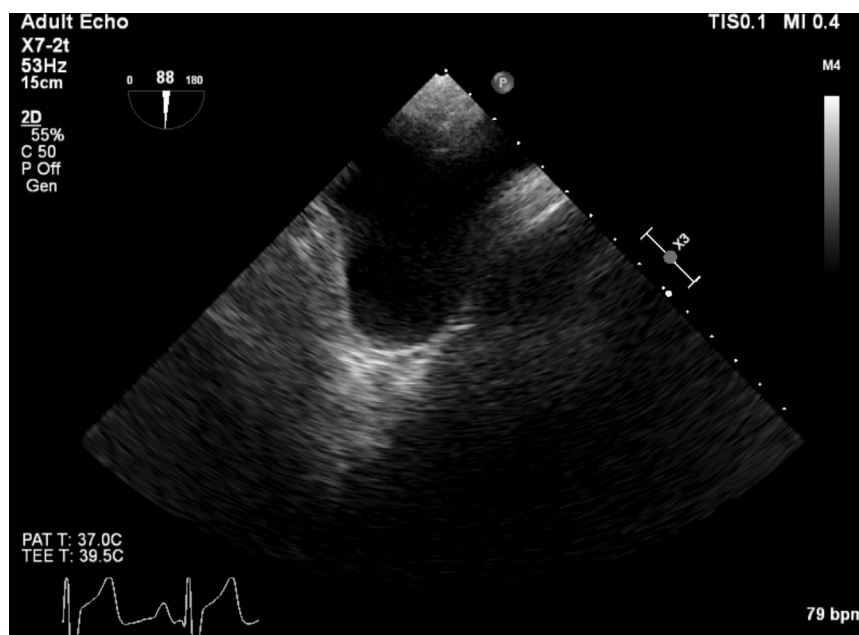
Midesophageal ascending aortic short-axis transesophageal echocardiography image showing aneurysmal dilatation of the main and right pulmonary arteries with relative sparing of the left pulmonary artery.
